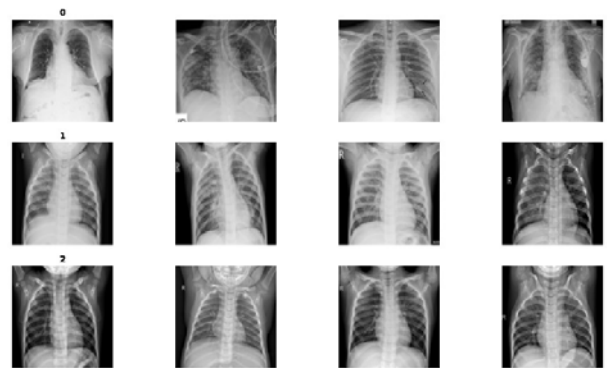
Sample X-ray images of three classes; 0: COVID, 1: Viral Pneumonia, 2: NORMAL from the chest X-ray database
